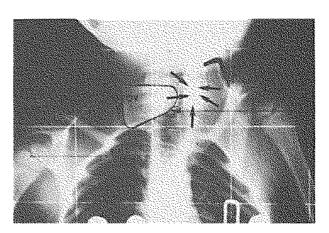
Preoperative anteroposterior radiograph showing the Sprengel deformity of the left shoulder with one of the two omovertebral bones extending from the medial border of the scapula to the transverse process of the fifth cervical vertebra (arrows). In this view, the omovertebral bone which was lying in the levator scapulae muscle is not visible. On the right side a single and large omovertebral bone (ov) is also visible on this anteroposterior view. The two superomedial angles of the two scapulae are underlined. C6: 6th cervical vertebra.
